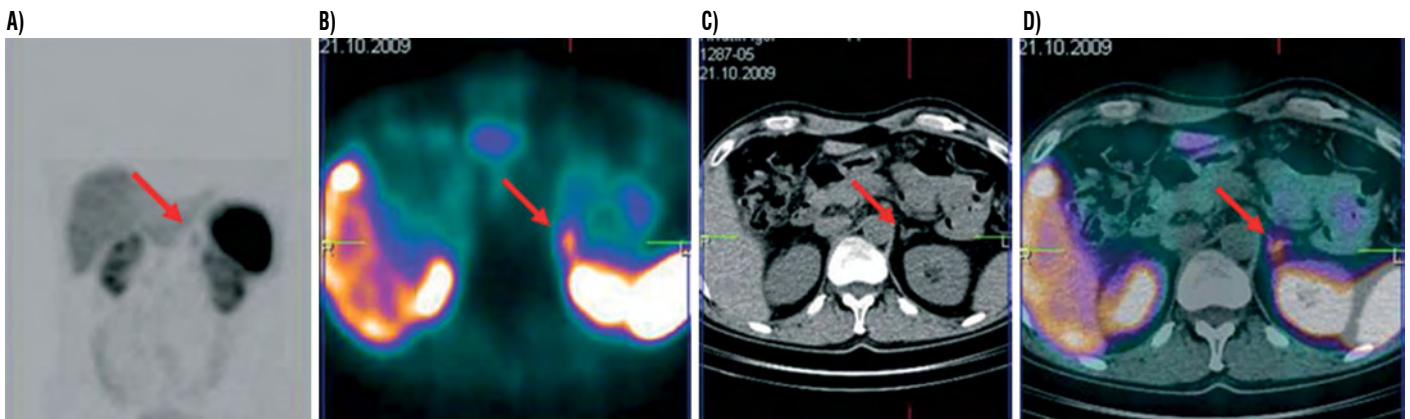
99mTc labelled somatostatine analogue octreotide: Increased tracer uptake in the upper abdomen (arrow), (A) MIT, (B) SPECT, (C) CT normal left adrenal gland, (D), Fused image: uptake is located in the normal adrenal gland - physiological uptake
